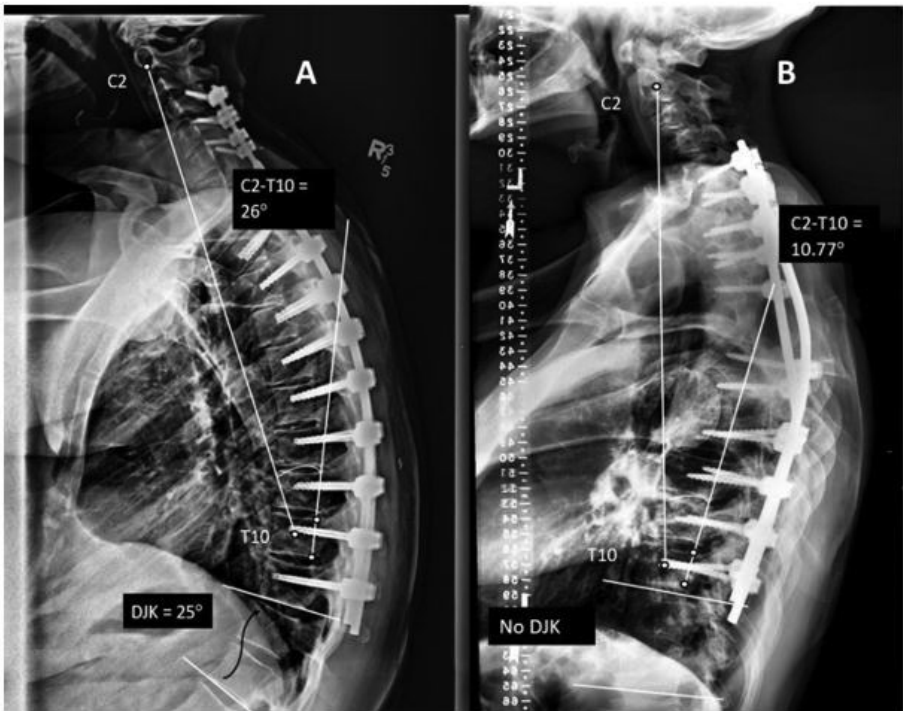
(A) Postoperative x-ray of under-corrected patient as evidenced by a larger C2-T10 SA of 26° who developed severe DJK. (B) Postoperative x-ray of patient with good correction with a C2-T10 SA of 10.77° with no DJK present.
